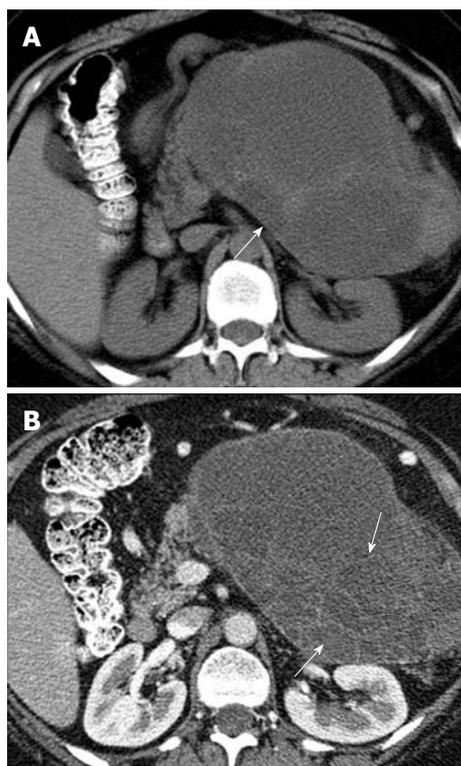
A 48-year-old woman with left upper quadrant pain. A: Axial non-contrast computed tomography (CT) scan of the abdomen shows a heterogeneous mass (arrow) in the left upper quadrant; B: Axial contrast-enhanced CT of the abdomen shows enhancing septa (arrows) within the mass.
